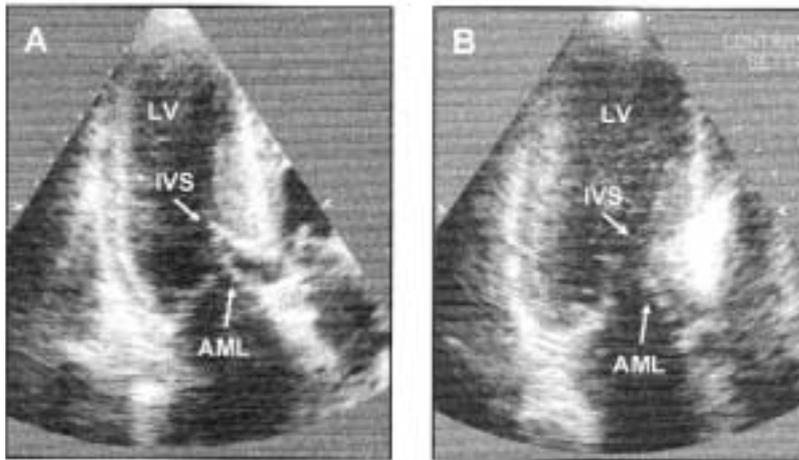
A: echocardiographic apical 4-chamber view in a patient with hypertrophic cardiomyopathy. B: injection of myocardial echocontrast into a septal perforator branch shows distribution of contrast confined to the target area, i.e. the area of contact, during systole, between mitral valve leaflets and the interventricular septum (IVS). AML = anterior mitral leaflet; LV = left ventricle.
